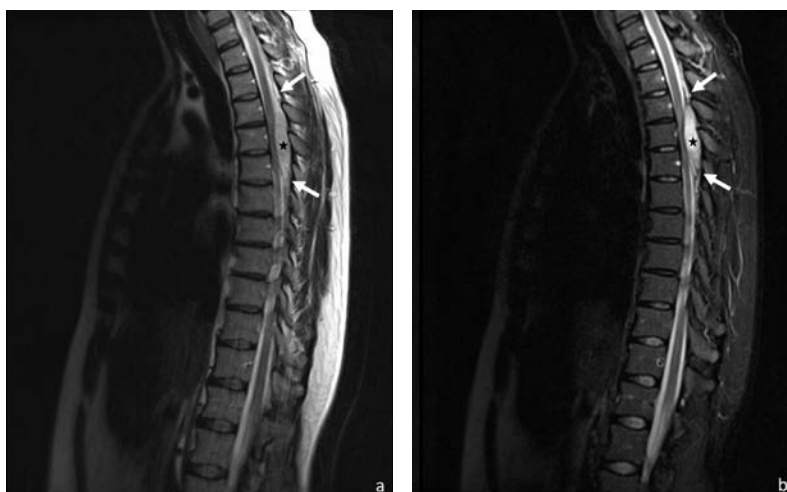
Sagittal T2-weighted (a) and corresponding STIR (b) images show a spindle-shaped epidural lesion spanning the T3 to T6 levels, consisting of a central fusiform component (star) with moderately high T2 signal and peripheral paraspinal components (white arrows), with signal characteristics consistent with fat (high T2 signal with suppression at STIR).
